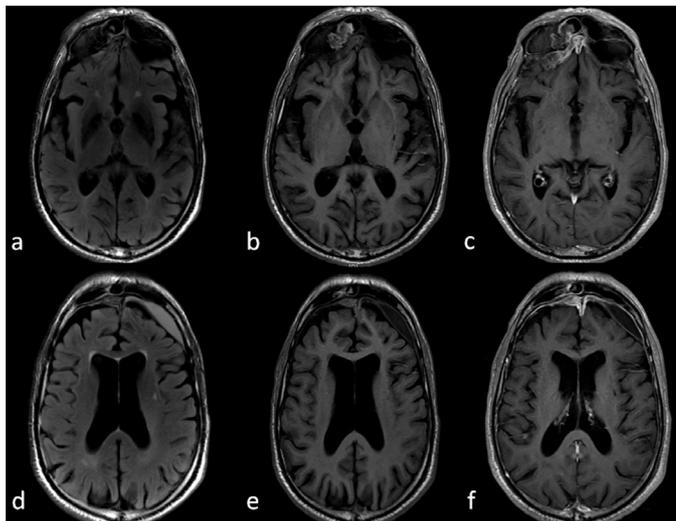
Cranial MRI studies showed left frontal empyema and an irregular hyperintense lesion originating from the right frontal sinus. (a,d) T1 FLAIR sequence, (b,e) T2 FLAIR sequence, (c, f) T1-weighted images with contrast
